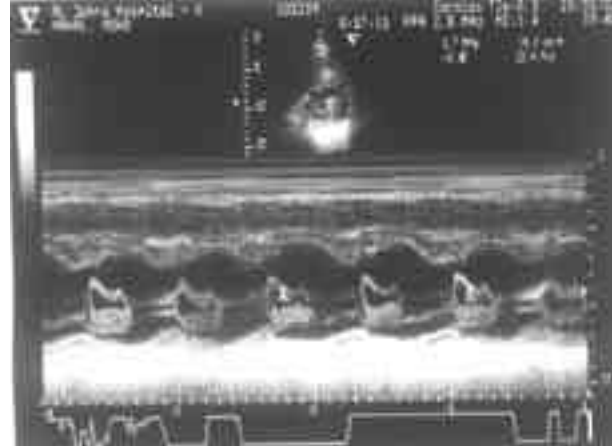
M-mode echocardiography of the heart showing the vegetation (arrow) between the two leaflets of the mitral valve
